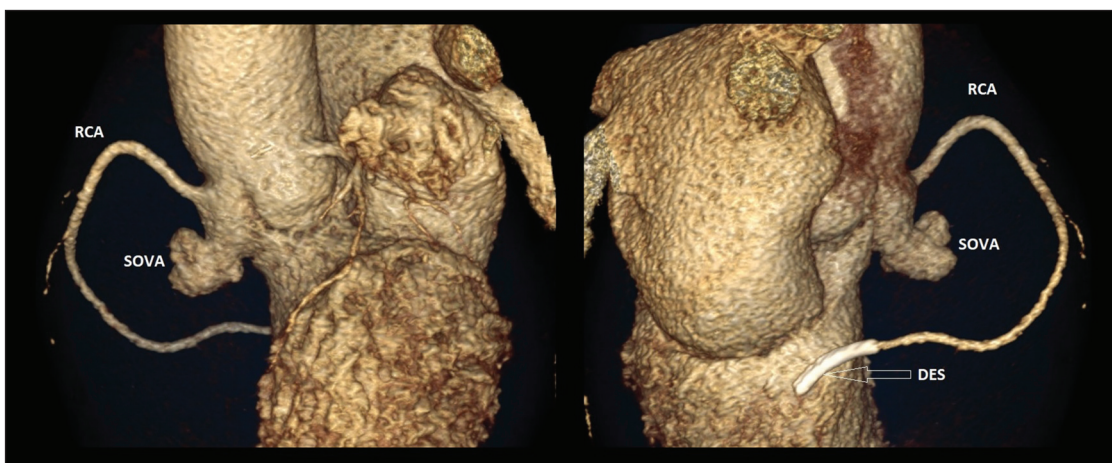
Coronary computed tomography angiography (CCTA). Left side: anterior view. Right side: right posterior view. DES – drug-eluting stent; RCA – right coronary artery; SOVA – sinus of Valsalva aneurysm.
